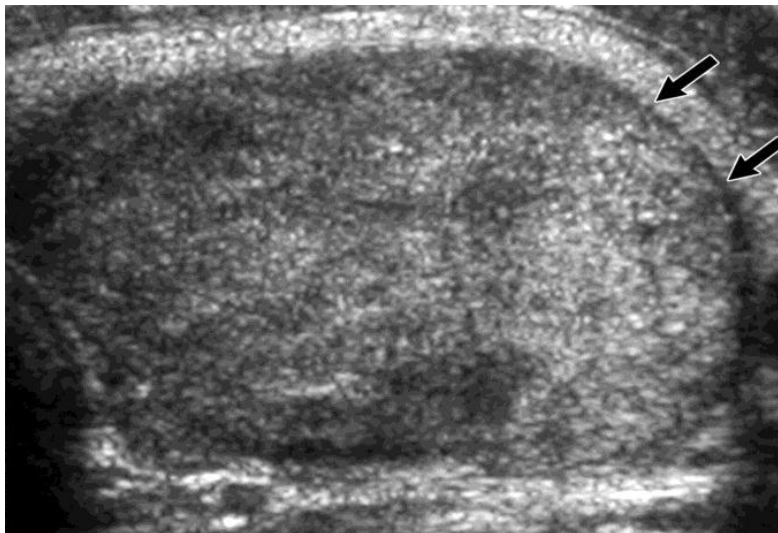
longitudinal grey scale sonogram shows a well-defined hyper echoic nodule (arrows) in the left lobe of thyroid gland suggestive of a follicular lesion. ([www.wikipedia.com](http://www.wikipedia.com))
